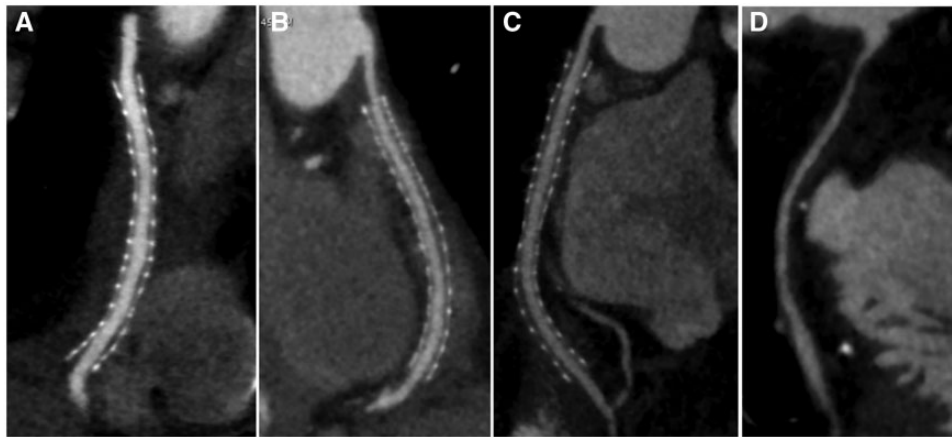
CT angiogram of VEST-supported (A–C) and non-supported (D) vein grafts. (A–C) Normal CT angiogram of three different patent VEST-supported vein grafts to the right coronary artery. (D) Normal CT angiogram of unsupported vein graft to the left territory.
